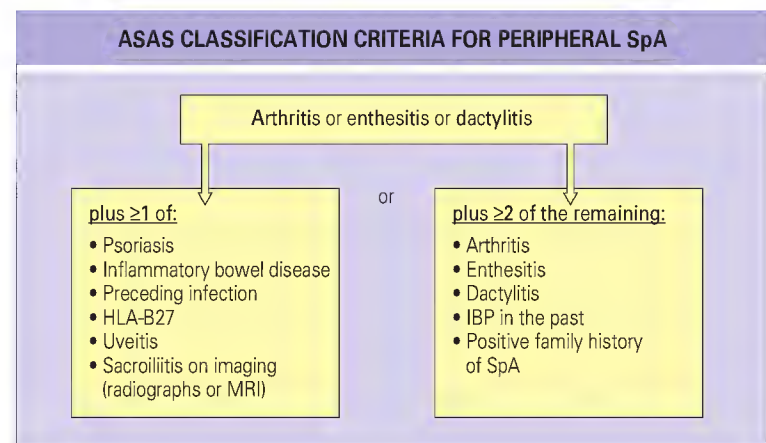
Assessment of SpondyloArthritis international Society (ASAS) endorsed criteria for classifying peripheral spondyloarthritis (SpA). Patients have either peripheral arthritis, enthesitis, or dactylitis with at least one of SpA features shown in the left box or at least two SpA features shown in the right box. IBP, inflammatory back pain; MRI, magnetic resonance imaging. (Modified with permission from Rudwaleit M, van der Heijde D, Landewé R, et al. The Assessment of SpondyloArthritis international Society classification criteria for peripheral spondyloarthritis and for spondyloarthritis in general. *Ann Rheum Dis* 2011;70:25-31.)
